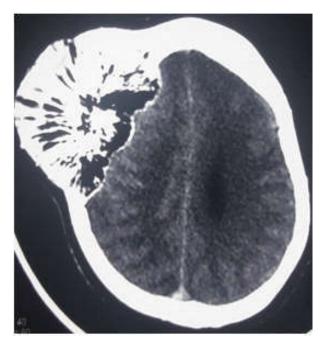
CT scan of the brain* revealed mixed dense trabeculated intraosseous lesion in right frontotemporoparietal calvarium with intracranial expansion of the mass causing squashing of right lateral ventricle with minimal midline shift.
